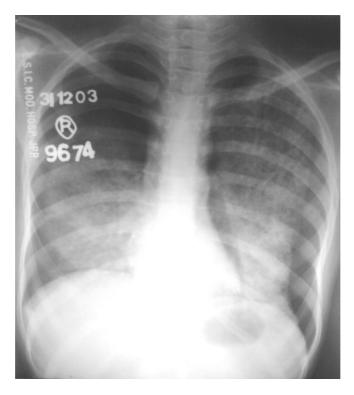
X-ray chest showing bilateral pneumothorax with underlying miliary tuberculosis on both sides.
